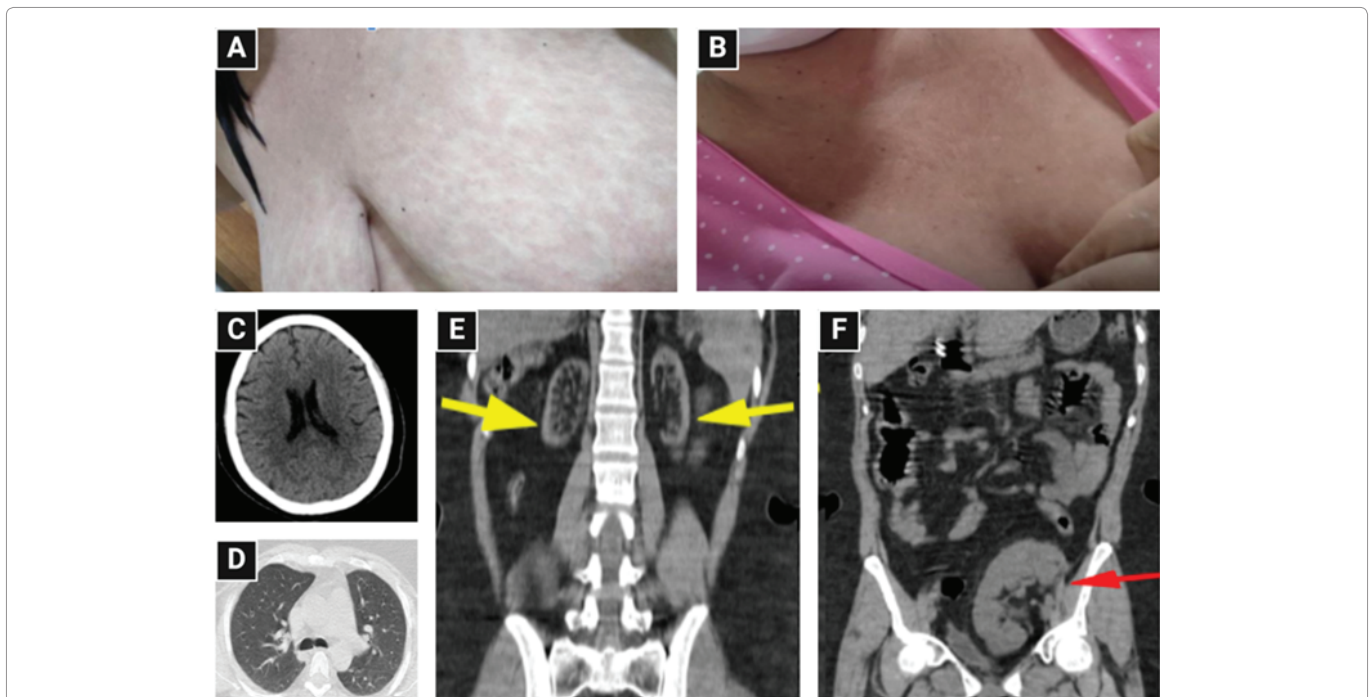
Clinical and radiological findings of the patient. (A) Morbilliform rash at admission. (B) Improvement of the morbilliform rash after 36 hours. (C) Cranial CT scan showing: Normal cortical sulci and brain cisterns for the patient's age. The brain parenchyma exhibits normal morphology and attenuation. No significant midline shift is observed, and there are no signs of intra- or extra-axial collections or masses. (D) Chest CT showing: Absence of pleural effusion. Mild reticular and ground-glass opacities in the subpleural region of the middle lobe, nonspecific. The rest of the lung parenchyma is without significant consolidations. (E) Abdominal CT, sagittal view, showing: Small kidneys with signs of advanced chronic nephropathy. (F) Abdominal CT, sagittal view, showing: Renal graft in the left iliac fossa with typical characteristics.
